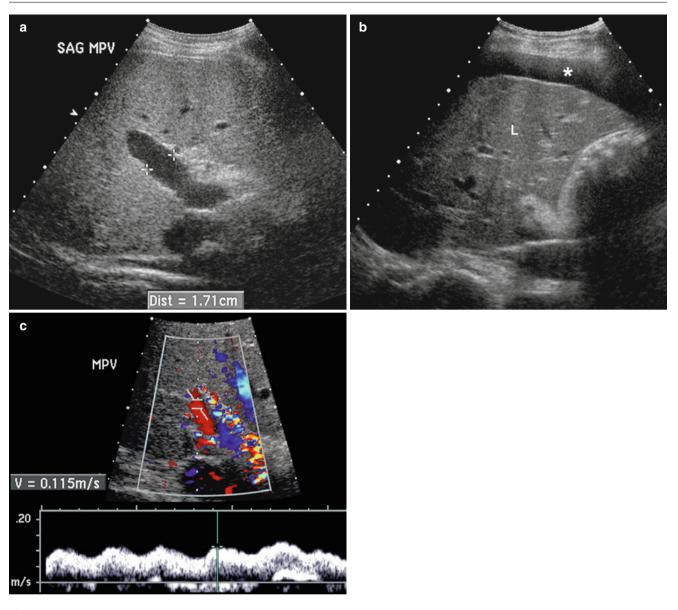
Portal hypertension. (a) Grayscale sonogram in a patient with portal hypertension demonstrating dilatation of the main portal vein to >1.7 cm (calipers). (b) Grayscale image from another patient
